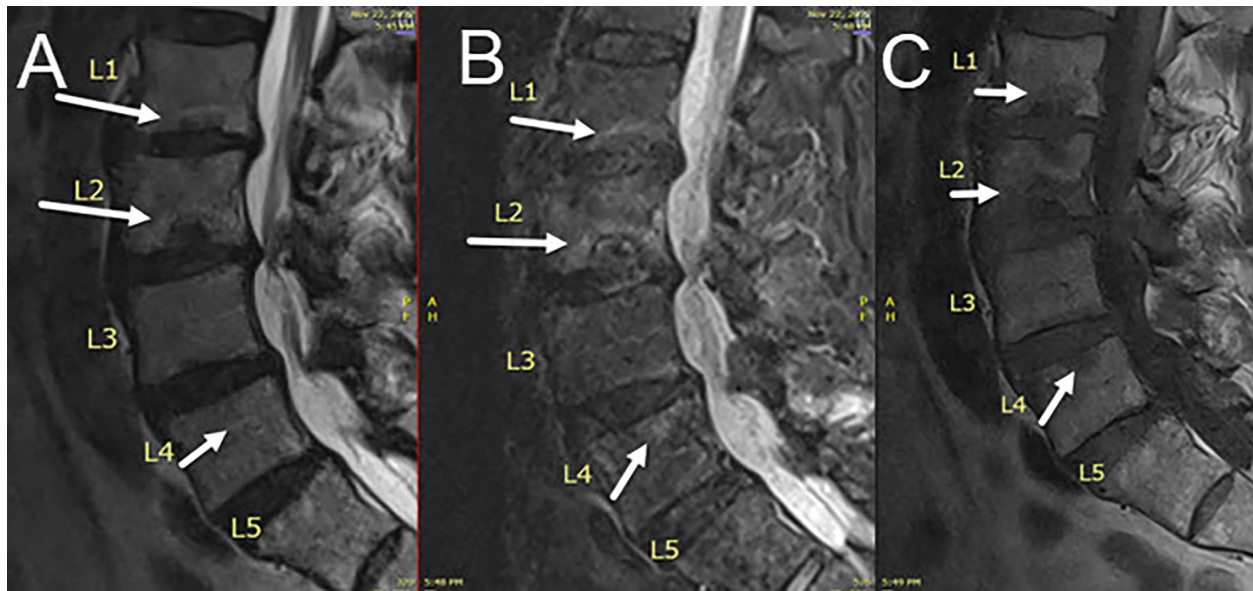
Sagittal T2-weighted (A), short T1 inversion recovery (B), and sagittal T1 weighted (C) magnetic resonance images of a patient with old injury from parachuting. Panels A, B, and C show Modic 1 and Modic 2 changes around Schmorl's nodes at L1–L4 (white arrows at each VEP disruption). After basivertebral nerve ablation L1–L5, the visual analog scale improved 8 cm to 0 and the Oswestry Disability Index improved 40 points from 52 to 10 at the last follow-up.
